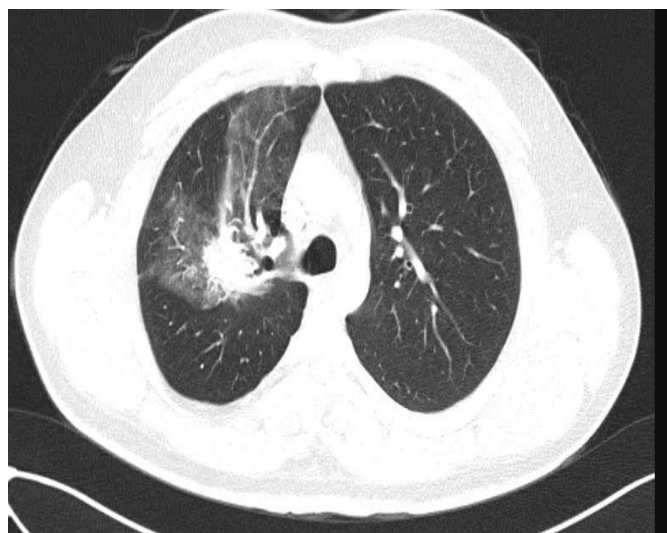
Computed tomography showing bleeding in the middle zone of the right lung
